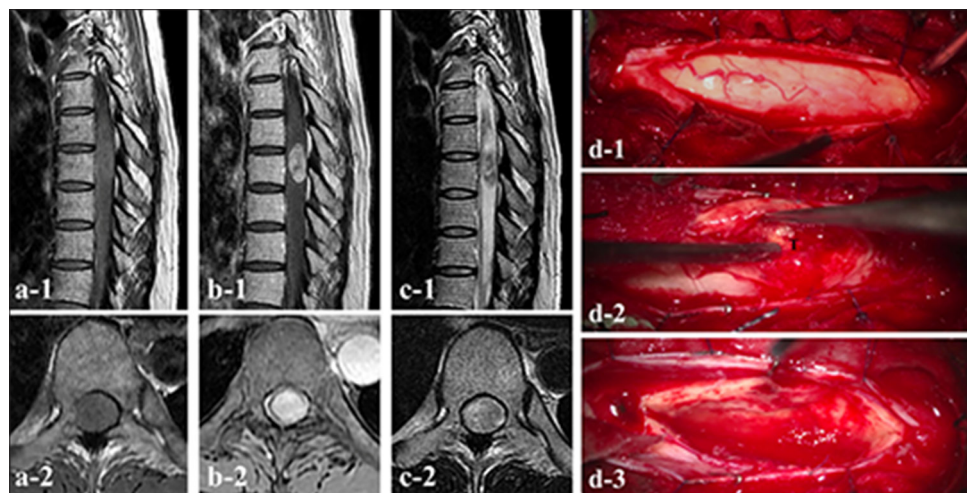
(a-c) Preoperative magnetic resonance imaging (MRI) on initial admission shows a well-defined intradural intramedullary lesion in the region of thoracic vertebrae (Th)7-8. Lesions are hypointense on (a-1: sagittal view, a-2: axial view) T1-weighted imaging (WI) and hypointense on (b-1: sagittal view, b-2: axial view) T2-WI. The lesion appears enhanced following administration of (c-1: sagittal view, c-2: axial view) gadolinium (Gd). (d-1, d-2) Intraoperative findings reveal a soft, yellow lesion below the incision site. No adhesions are evident between the tumor and dura mater. (d-3) The tumor margin appears free of the spinal cord and is carefully dissected and removed. T, tumor.
